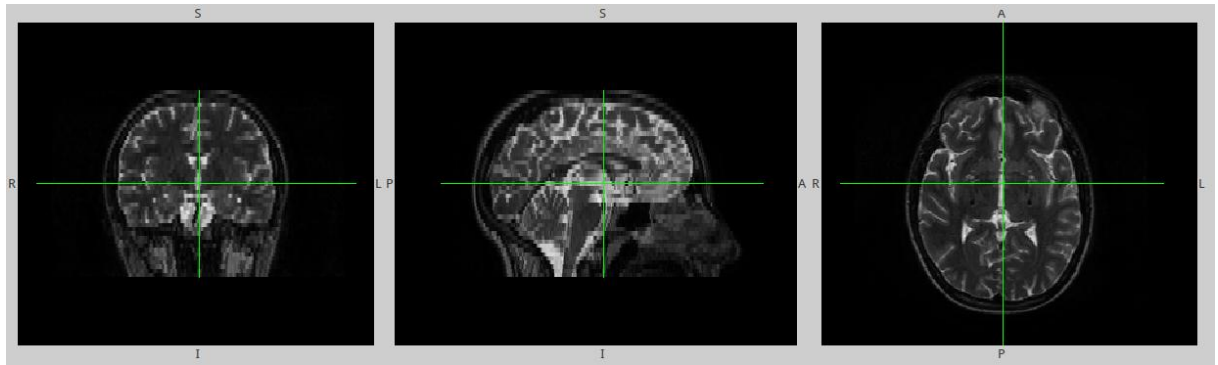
Coronal, sagittal and axial planes of T2-weighted image of a subject of the study.
